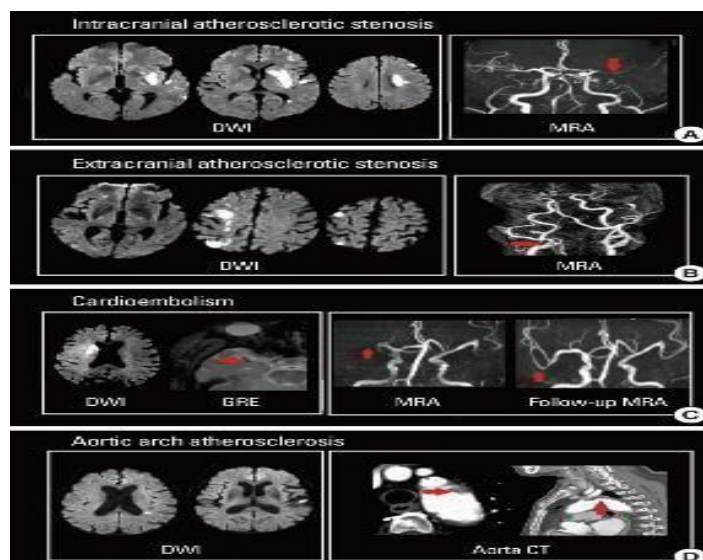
DWI lesion patterns according to stroke subtypes. (A) Intracranial atherosclerotic stenosis, (B) extra cranial atherosclerotic stenosis, (C) cardio embolism, and (D) aortic arch embolism.
